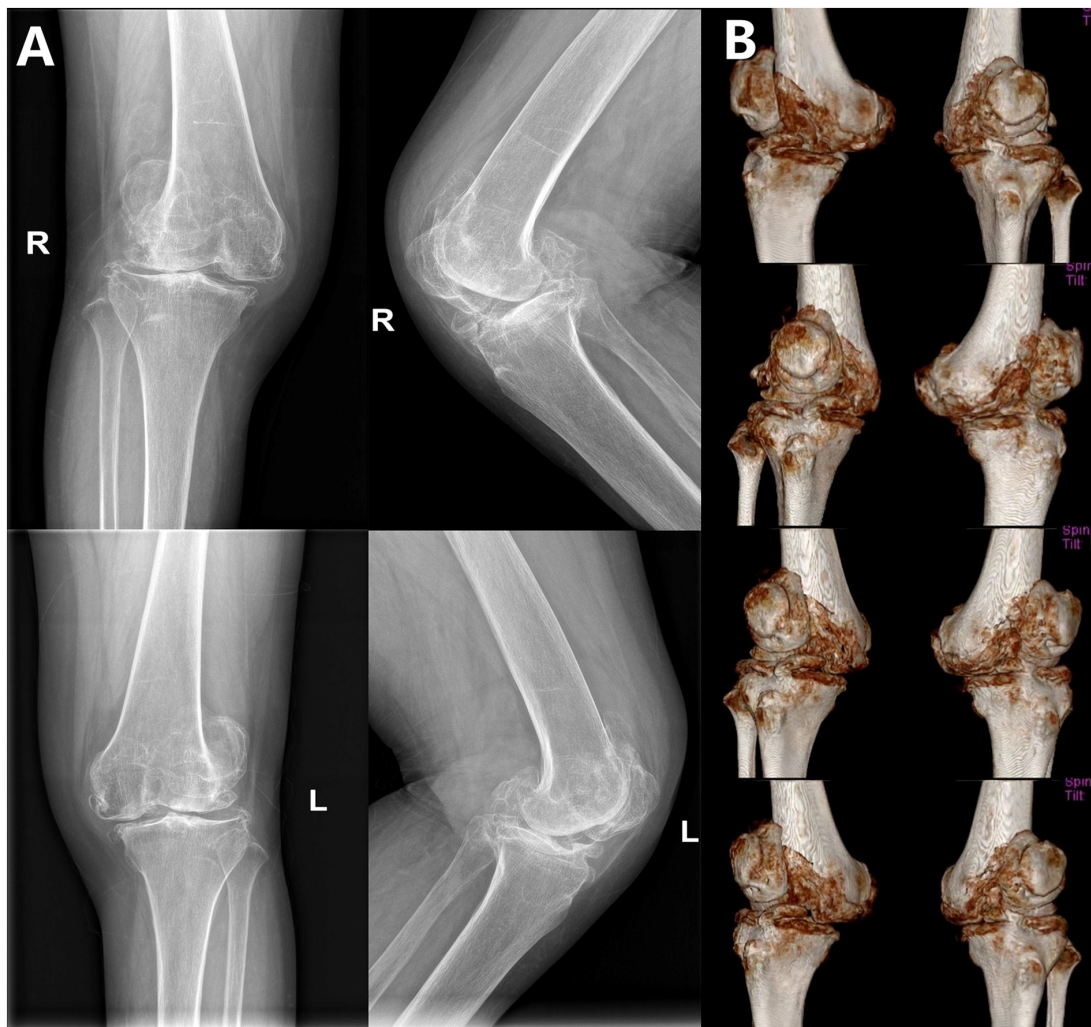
Preoperative knee CT and X-ray. (A) Preoperative anteroposterior and lateral knee X-rays showing severe osteoarthritis with lateral patellar dislocation. (B) CT three-dimensional reconstruction showing subluxation of the tibiofemoral and patellofemoral joints, along with marked osteophyte proliferation. CT, computed tomography.
